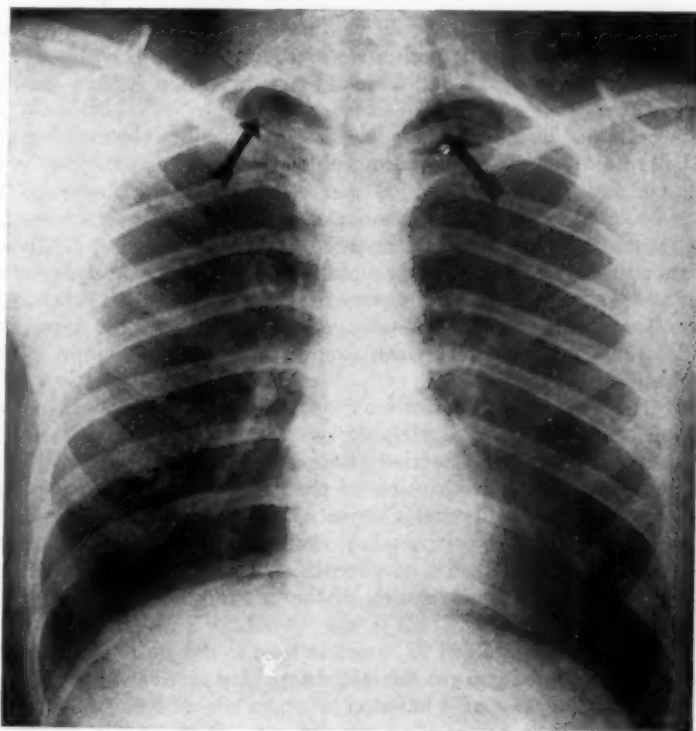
Roentgenogram of the chest. The arrows indicate the air in the soft tissues of the neck extending from the superior mediastinum.
